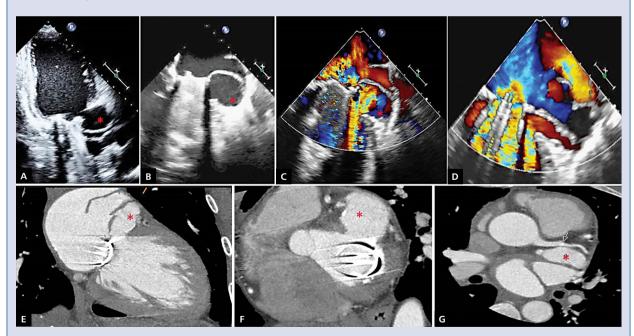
Transthoracic (A) and transoesophageal echocardiography (TEE) (B, C) images revealing a large cavity (*) of 39×33 mm with systolic expansion in the basal segment of the anterolateral left ventricular (LV) wall, below the prosthetic mitral annulus plane, communicating with the LV through a neck of 13 mm, suggesting the presence of a left atrioventricular groove disruption; D. TEE with colour Doppler showing moderate regurgitation due to the presence of two paraprosthetic leaks; E–G. Cardiac computed tomography images of the previously described aneurysmal cavity (*) showing the anatomical relation with mitral valve annulus and circumflex artery (pointed out with an arrow), essential to delineate the surgical approach
